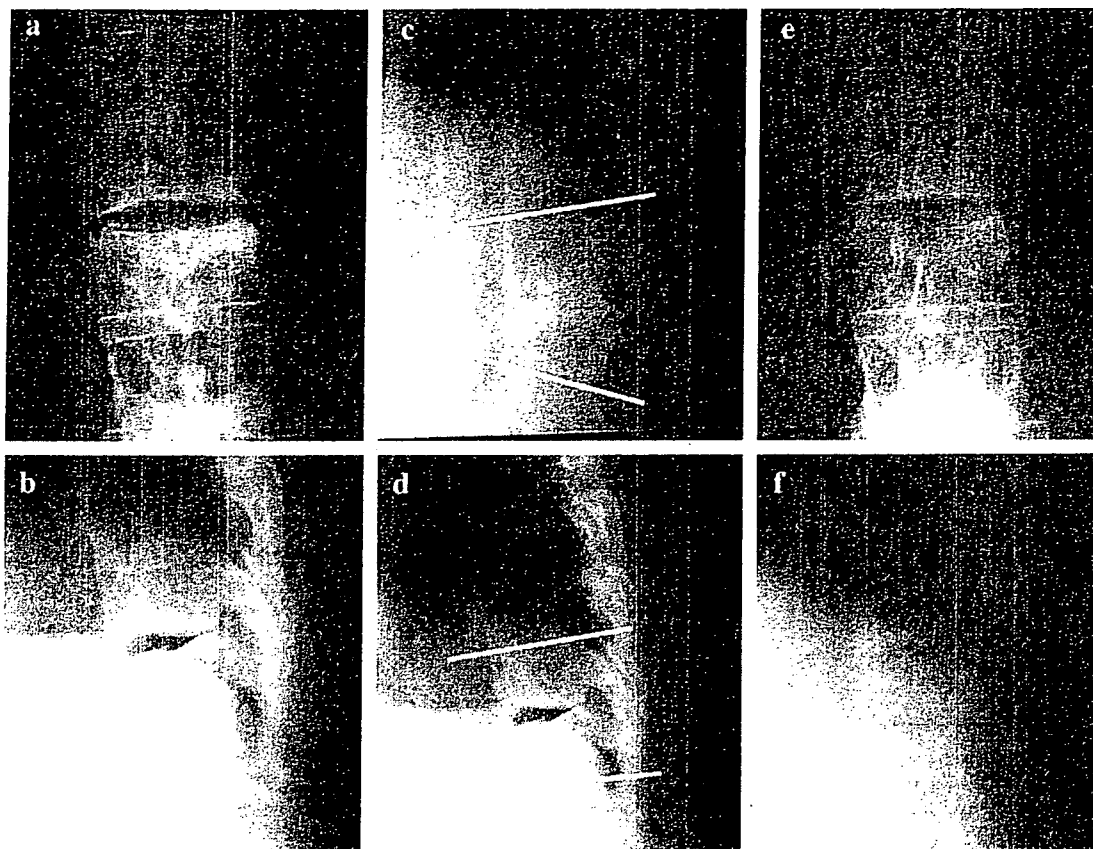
Radiographs of the thoracolumbar junction. (a, b) At referral (2 months after the third infusion of infliximab). Vacuum phenomenon in the intervertebral space and sclerosis of the adjacent margins of T11 and T12 are visible. (c, d) Lateral radiographs in flexion and extension positions at referral. Hypermobility between T11 and T12 is indicated (range of motion, 12.2°). (e, f) Two months before infliximab therapy. The initial changes of pseudoarthrosis are visible.
